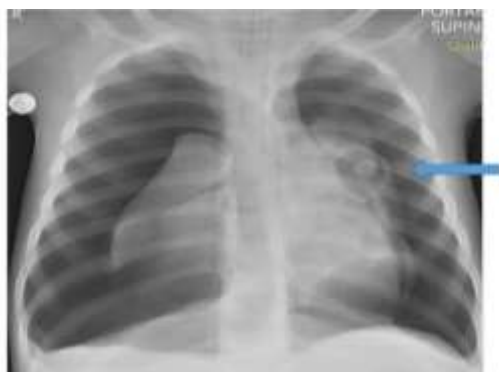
Chest X-ray showing bilateral pneumothorax and cavitary lesion with soft tissue density (arrow)
